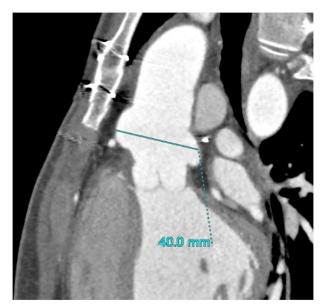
Postoperative (6 months) computed tomography scan of the neo-aortic root of an early patient operated on with a conventional reinforcement (before a switch to reimplantation) technique. The autograft wall appears to bulge through the coronary artery reimplantation holes.
